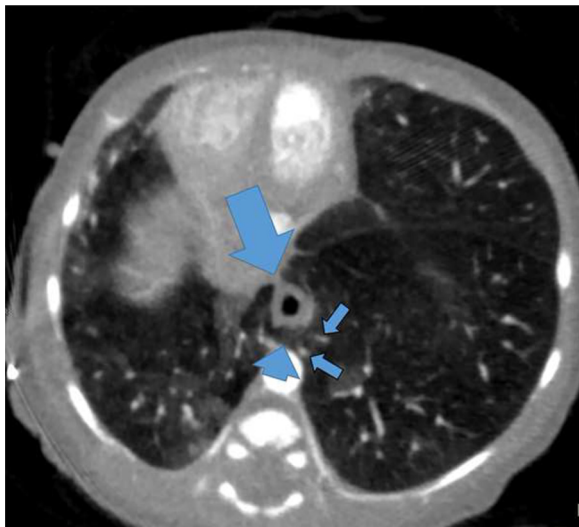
Axial chest CT angiography shows horseshoe isthmus (short arrow) surrounding the esophagus in almost 360 degrees (large arrow), with branches from the right pulmonary artery crossing through the isthmus to reach the left lower lobe (short arrows).
